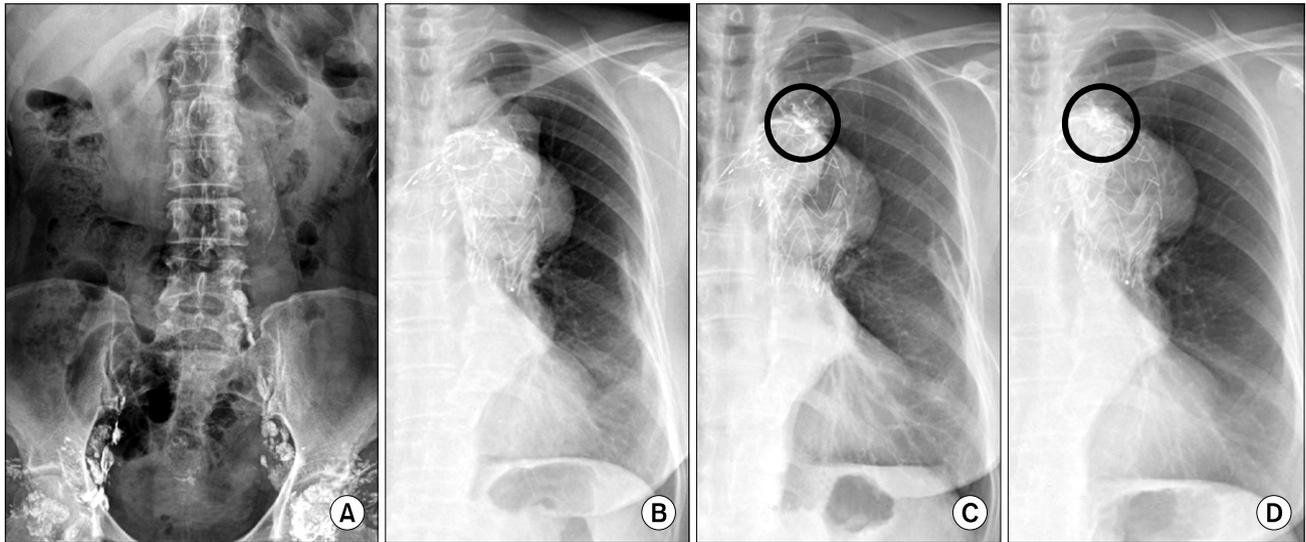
Chest X-ray obtained after TDE with lipiodol (circle). (A) After TDE. (B) Post TDE 3 days. (C) Post TDE 13 days (circle). (D) Post TDE 28 days (circle). TDE, thoracic duct embolization.
